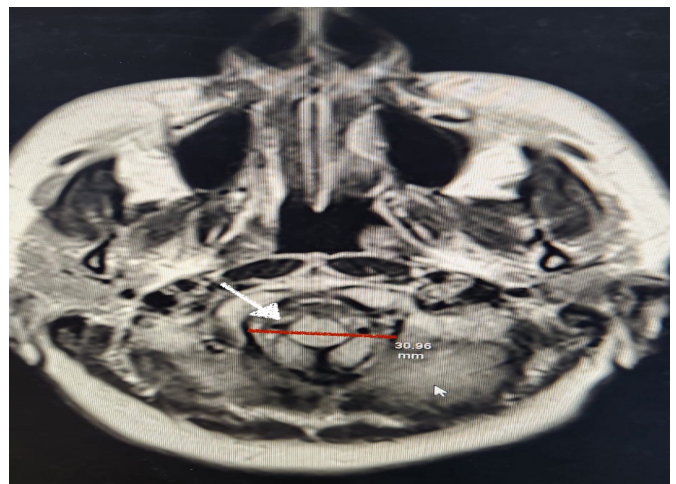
Magnetic resonance imaging (MRI) image showing the transverse diameter measurement of the foramen magnum (red line)
